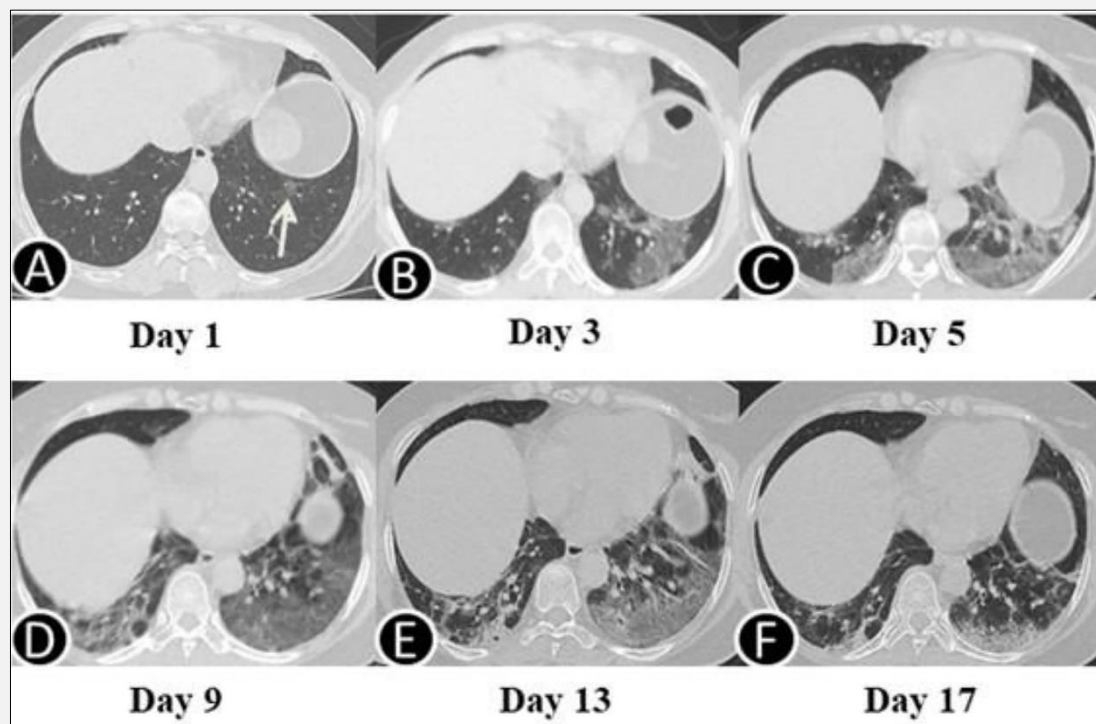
Dynamic change in chest CT images in a severe COVID-19 patient during hospitalization.
